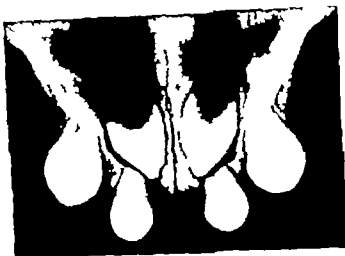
Roentgenogram of the upper jaw in case P B showing the pc shaped teeth
